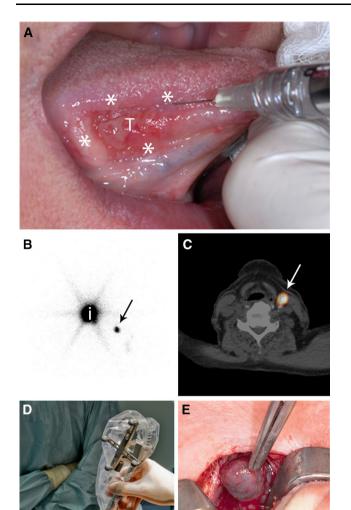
Sentinel node procedure in a patient with a lateral tongue carcinoma. a Peritumoral injections (*asterisk*) of ^{99m}Tc-labeled Nanocoll (*T* primary tongue carcinoma); b planar lymphoscintigraphy (*i* injection site; *arrow* sentinel node); c SPECT–CT (*arrow* sentinel node); d intraoperative detection using gamma probe; e sentinel node biopsy (*blue* and hot) (color figure online)
